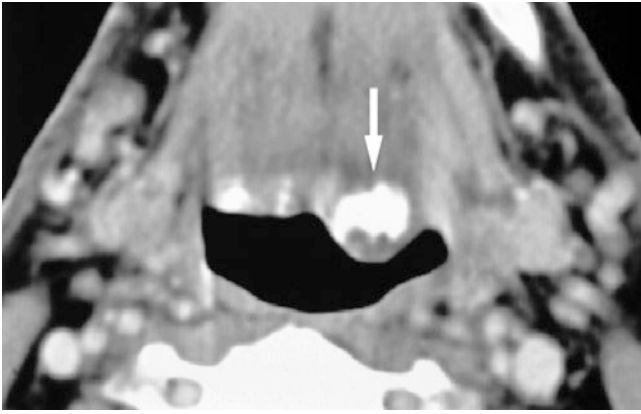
Calcification in lingual tonsil; 74-year-old female with painless swelling in posterior part of tongue. Axial CT image shows calcified mass in posterior part of asymmetric tongue (*arrow*)
